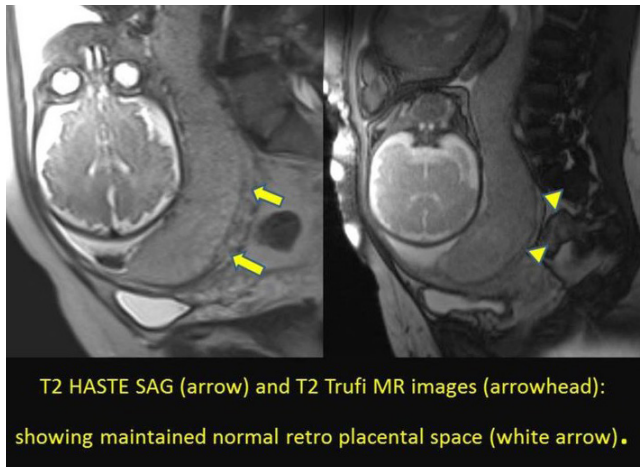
MRI image showing complete placenta previa.
